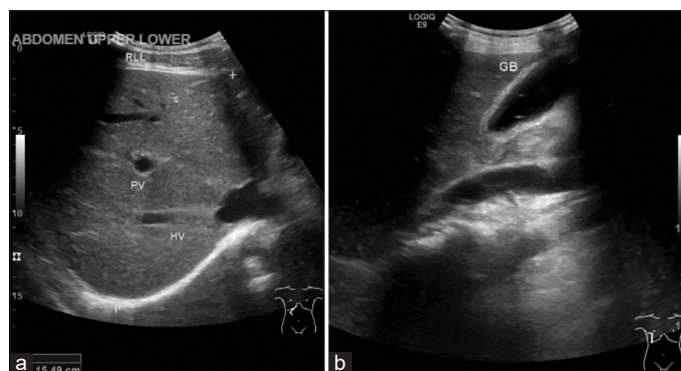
Abdominal ultrasound findings. (a) Abscess measuring approximately 12.49×11.9×17.19 cm located in segments VII and VIII of the right hepatic lobe; (b) Cholecystitis characterized by thickening and irregularity of the gallbladder wall
